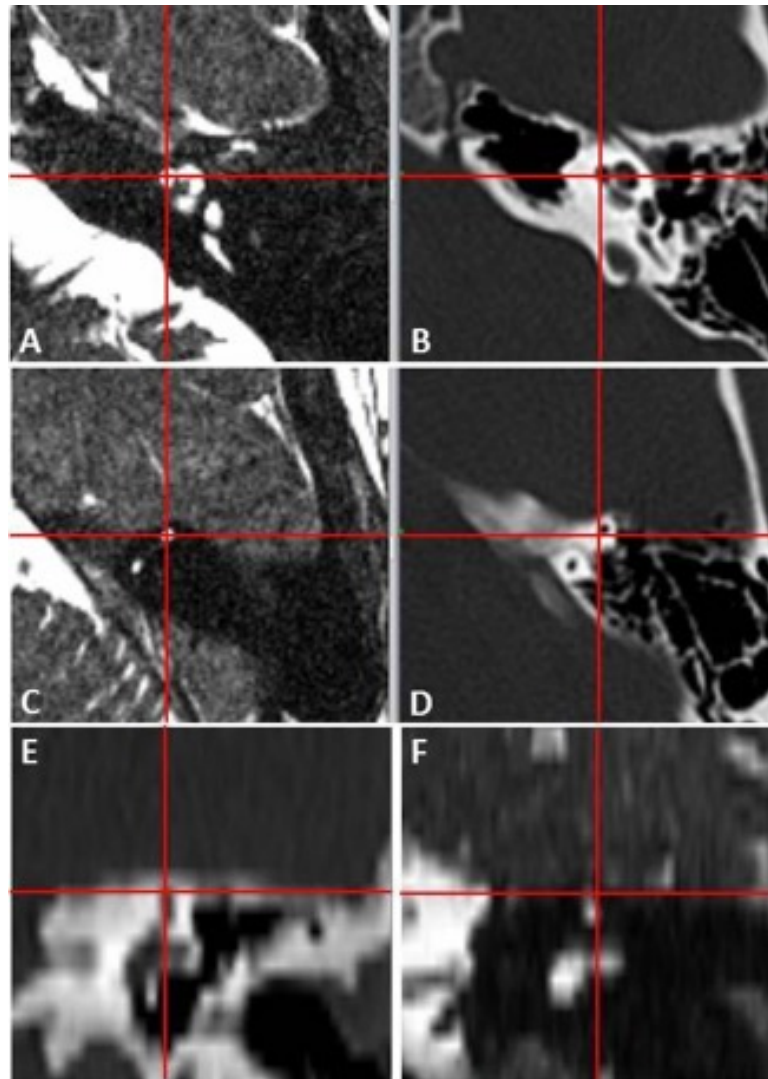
Submillimetre discrepancies between the location of the landmarks in the MRI and CT scans attributed to imaging distortion. The red lines cross in the centre of the cochlear canal at the most medial spiral turn in the pre-GKR MRI scan (A) but slightly off-centre in the post-GKR CT scan (B). Similar discrepancies between 0.5 and 1 mm were seen in the axial view (C and D) and coronal view (E and F) of the SCC (case 16).
